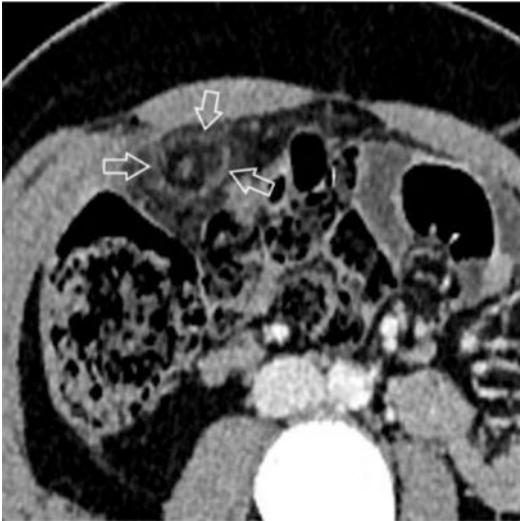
Appendagitis in a 14-year-old girl—CE-CT. A round fat-containing lesion is visualized in the right flank. There is a central vessel, the lesion seems surrounded by a capsule and there is peripheral inflammatory reaction as well
